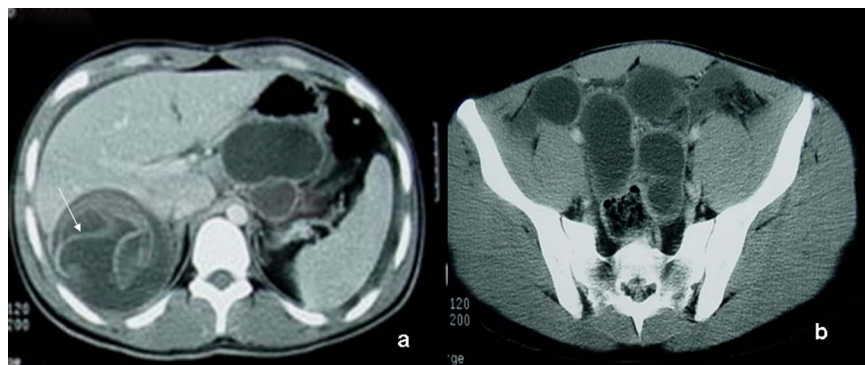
A CT scan showing the right hepatic cystic mass with the split-membrane sign (A; arrow) and multiple pelvic cystic masses of variable sizes (B).
